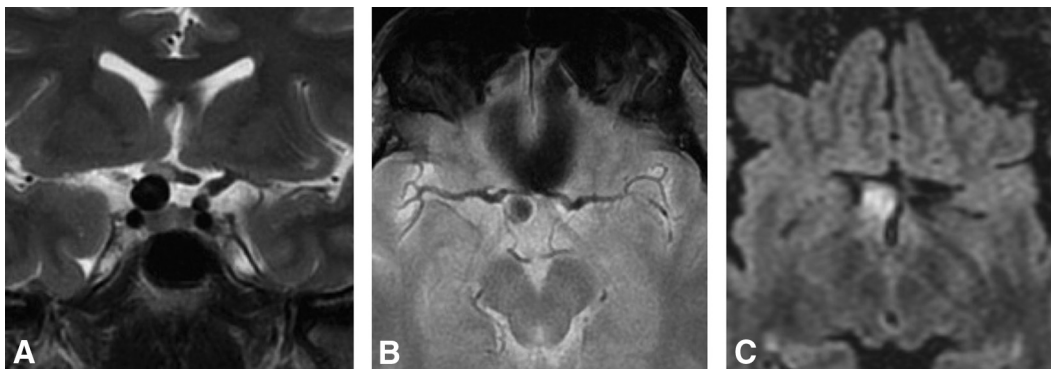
Internal carotid artery aneurysm. Coronal T2WI (A), axial gradient recalled-echo T2WI (B), and FLAIR (C) in a patient with a right internal carotid artery aneurysm. A 45-year-old man with a history of headache. Coronal T2WI (A) and axial FLAIR images (C) demonstrate an aneurysm of the right internal carotid artery. The optic chiasm is displaced, and there is an area of signal intensity change in the T2WI (A) and FLAIR (C), which indicates edema.
